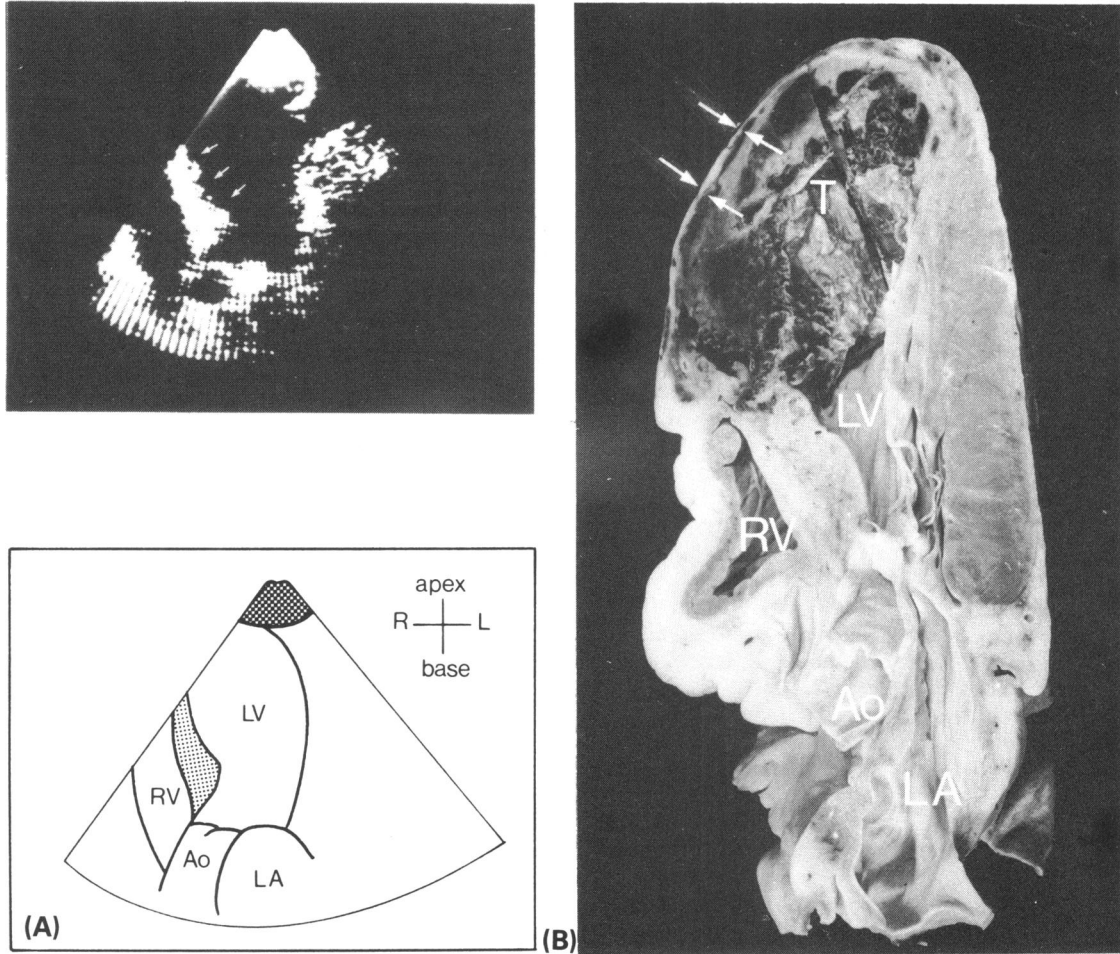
(A) End-diastolic three chamber view in a patient with an acute anterior infarction, who died 18 hours after admission. Note the obvious thinning of the septum (arrows) and distortion of the shape of the left ventricle. At the time of this study no intracavitary thrombus was identified. (B) A cross-section through the heart of the same patient comparable to the apical three chamber view. There is an extensive anteroseptal infarction with extreme wall thinning (arrows). Part of the left ventricular cavity is filled with thrombus (T).
